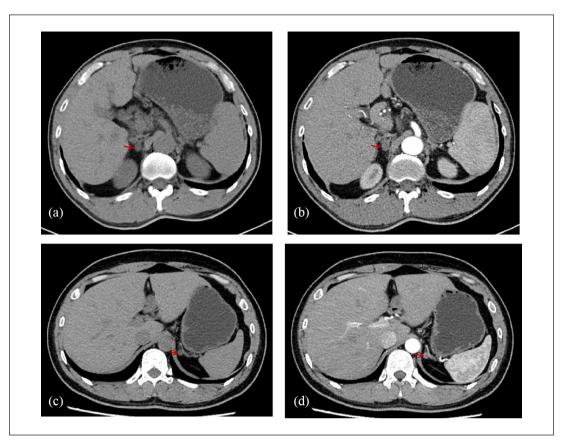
Results of adrenal contrast-enhanced CT of the two patients: (a) adrenal computed tomography scanning of patient I showing right adrenal adenoma (pointed by the red arrow), (b) adrenal computed tomography of patient I enhancement indicating a mildly intensified right adrenal adenoma (pointed by the red arrow), (c) adrenal computed tomography scanning of patient 2 showing left adrenal adenoma (pointed by the red arrow), and (d) adrenal computed tomography of patient 2 enhancement indicating a mildly intensified left adrenal adenoma (pointed by the red arrow).
